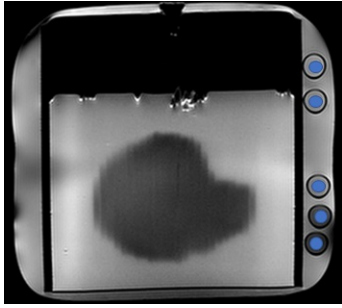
Echo of a MRI slice from cuboid B. ROI for acquisition of the mean R_2 and standard deviation are coloured in blue.
